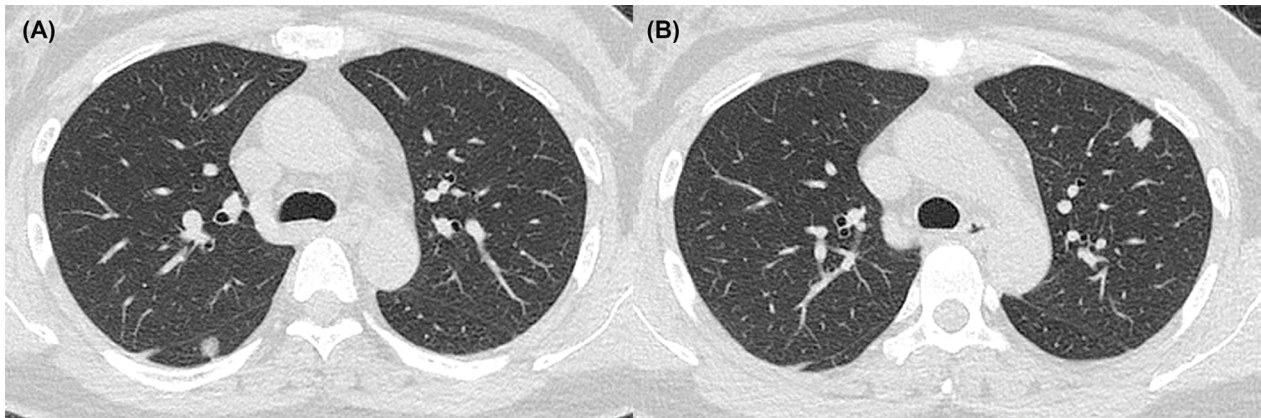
Computed tomography (CT) revealed 2 peripheral isolated pulmonary nodules, each around 1 cm in diameter. (A) One was in the superior segment of the right lower lobe and (B) the other was in the left upper lobe of the lung.
